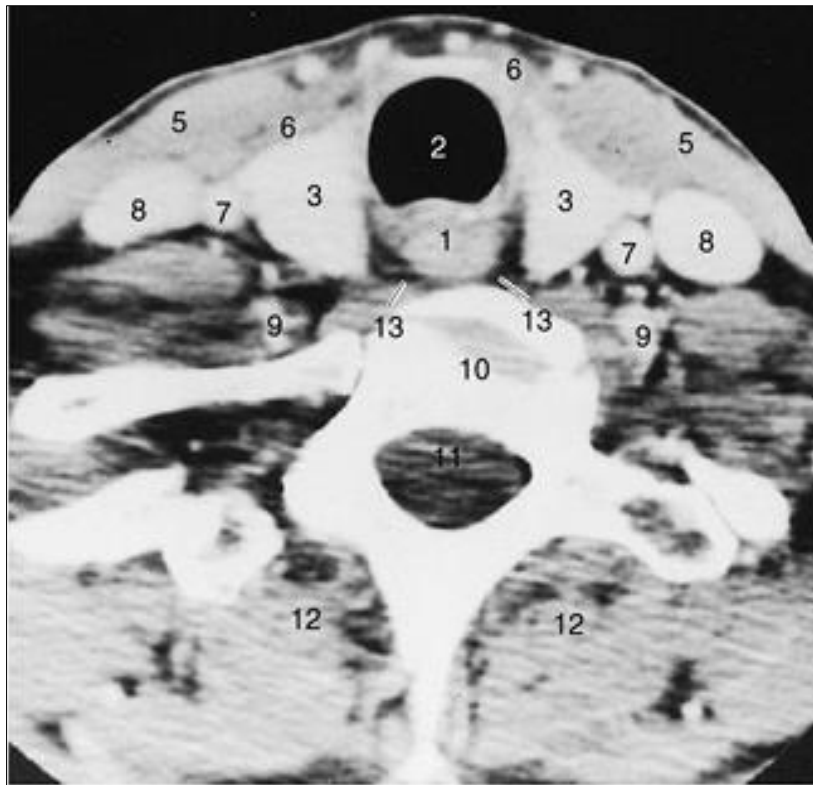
Cervical CT at the level of the thyroid gland
